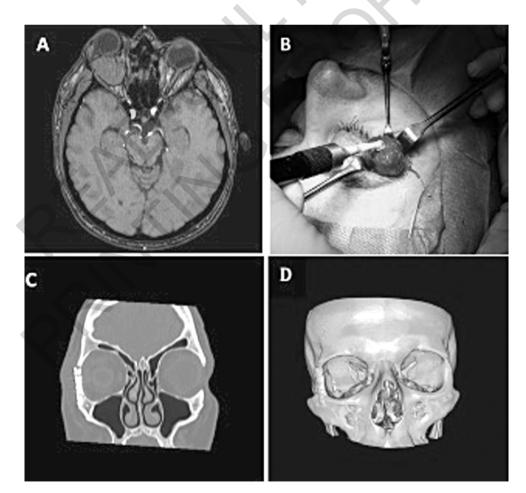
Clinical case of a patient suffering from orbital hemangioma. A) preoperative MRI image; B) intraoperative detail, removal using the cryostat; C) postoperative CT, axial view; D) postoperative 3D CT scan.
